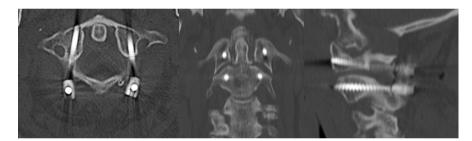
CT scan after surgery also confirms good positioning of screws.
